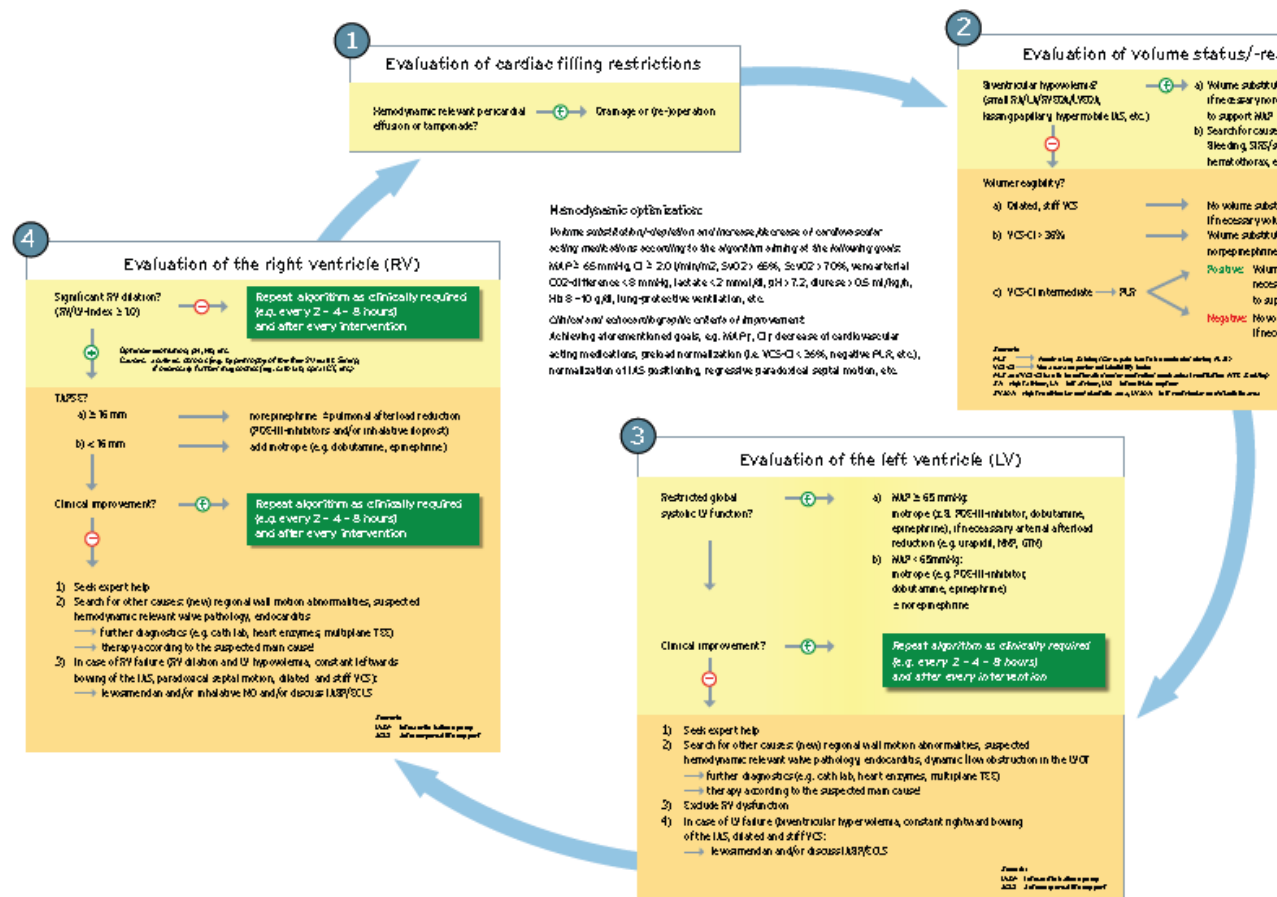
Algorithm suggesting the role of echocardiography in post-cardiac surgical hemodynamic management.
